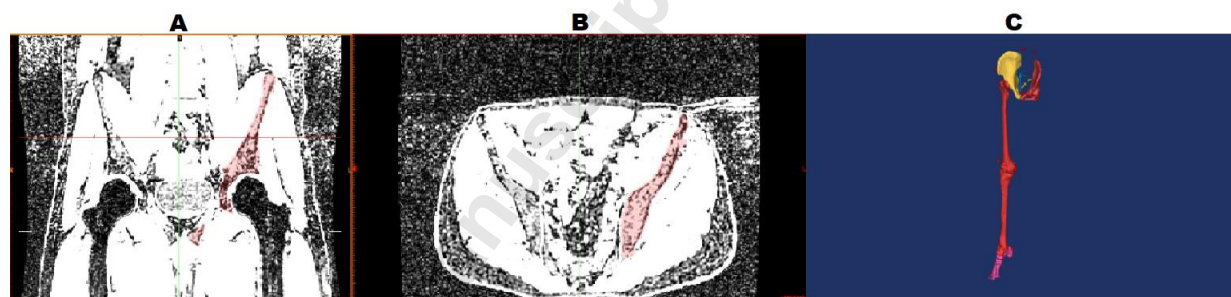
A) MRI Coronal view: Showing a mask of the left pelvis in one slice B) MRI Axial view: Showing a mask of the left pelvis in one slice C) Segmented lower limb 3D View.
